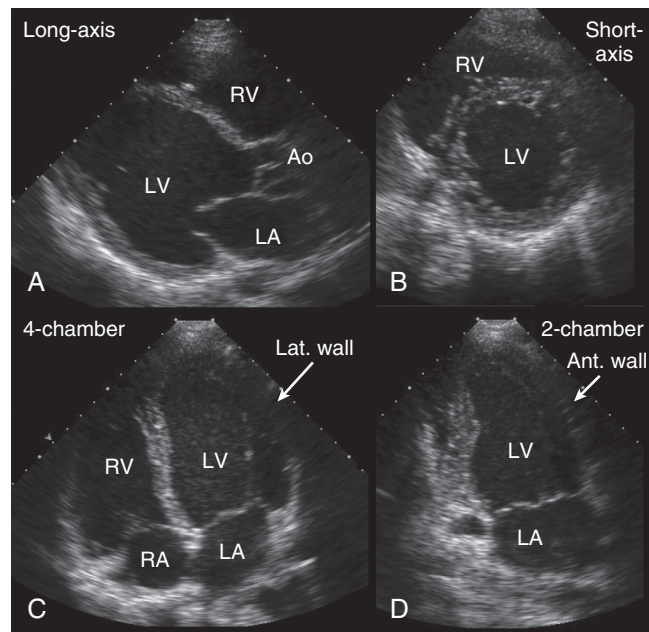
■ A, Parasternal long axis view in a patient with dilated cardiomyopathy shows the anteroseptum and posterior wall of the left ventricle. B, Parasternal short axis view in a patient shows a cross-section through the mid-portion of ventricles. C, Apical four-chamber view shows the lateral (Lat. wall) and inferoseptal walls of the left ventricle (LV) and the free wall of the right ventricle. D, Apical two-chamber view shows anterior (Ant. wall) and inferior walls of the LV.
